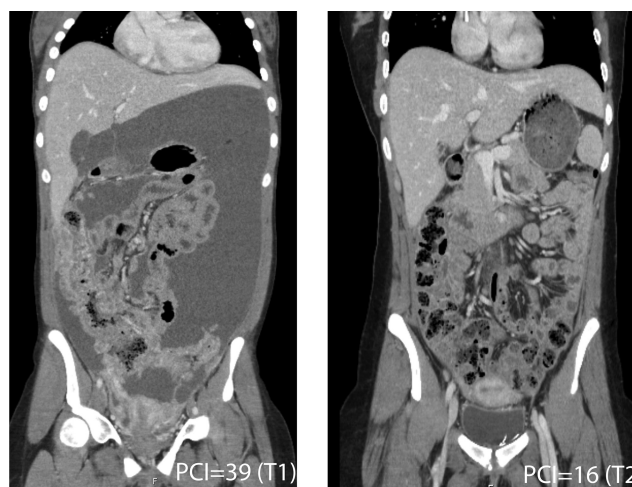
CT images before (T1, PCI = 39) and after (T2, PCI = 16) platinum/pemetrexed chemotherapy.
